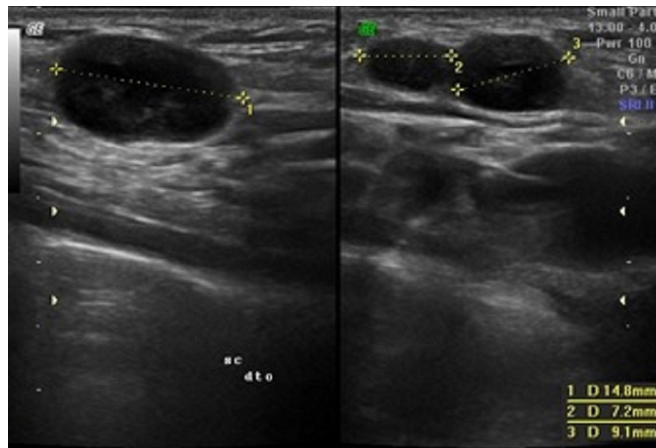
The first ultrasound of the 13-year-old boy showing three nodular structures, the largest with a bigger axis of 14.8 mm, both well-delineated.
